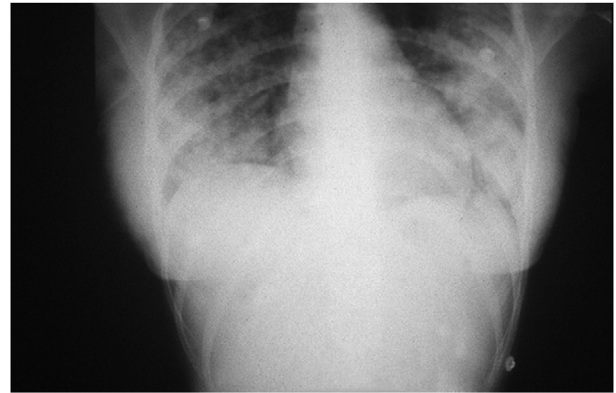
Portable chest radiograph of a man with acute pulmonary haemorrhage, showing bilateral interstitial shadowing.
